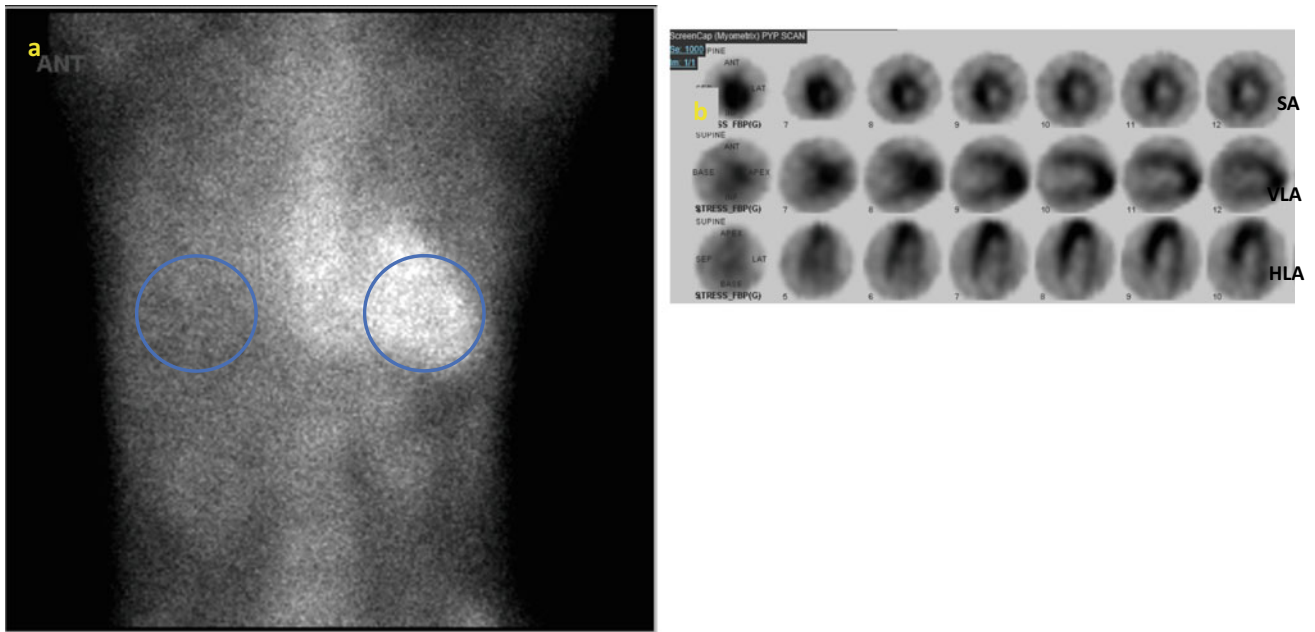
a Technetium-99 m pyrophosphate (PYP) scintigraphy 1 h after radiotracer injection showing myocardial PYP uptake with a semiquantitative or visual grade of 3 and heart-to-contralateral lung (H/CL) ratio of 1.6. b PYP SPECT confirming myocardial radiotracer uptake. SA, short axis; VLA, vertical long axis; HLA, horizontal long axis
